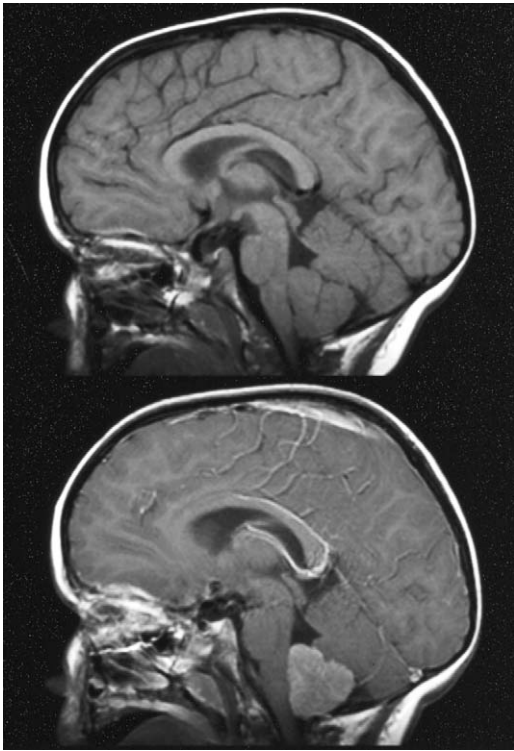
A typical choroid plexus papilloma arising in the fourth ventricle. T1-weighted images before (*top*) and after (*bottom*) gadolinium enhancement are shown.
